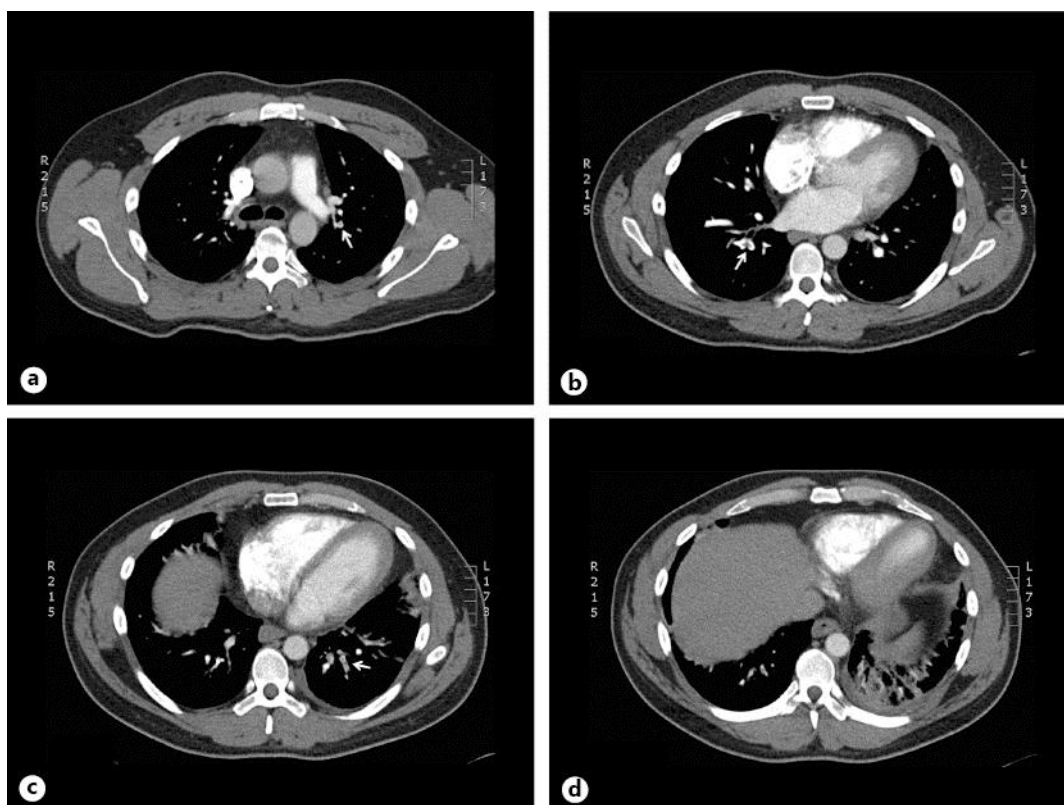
CT angiography demonstrating multiple segmental pulmonary emboli and subsequent pulmonary infarct. a A filling defect consistent with PE is noted in the left lower lobe segmental artery (arrow). b A filling defect consistent with PE is noted in the right lower lobe segmental artery (arrow). c Another filling defect noted in the left lower lobe segmental artery (arrow). d Patchy opacities seen in left lower lobe most consistent with pulmonary infarct.
